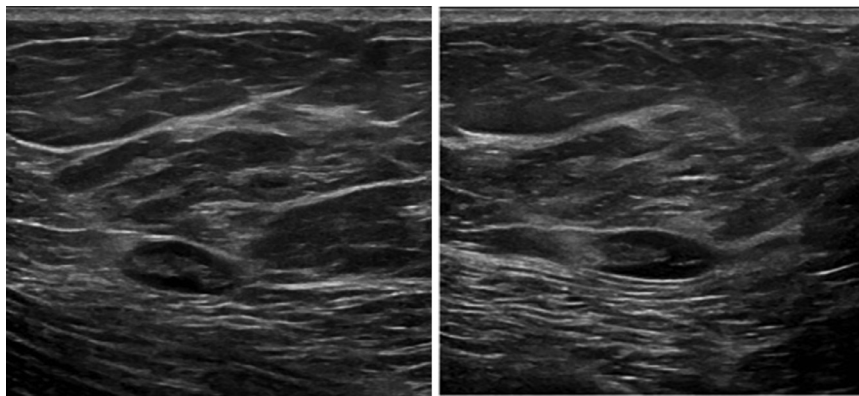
Radial (left) and anti-radial (right) gray scale ultrasound images of the right breast demonstrate a 1.5 cm mass in the upper inner breast which resembles an intramammary lymph node with mild cortical thickening. This correlates with the asymmetry on mammogram.
